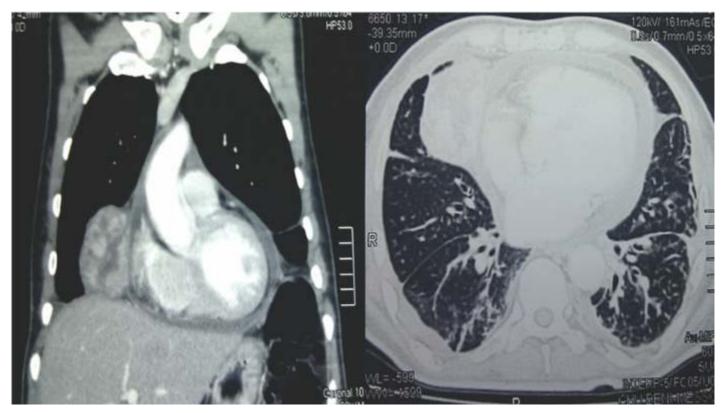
CT scan: on the left, mass anterolateral to heart; on the right, a thin-section CT scan showing bilateral bronchiectasis
